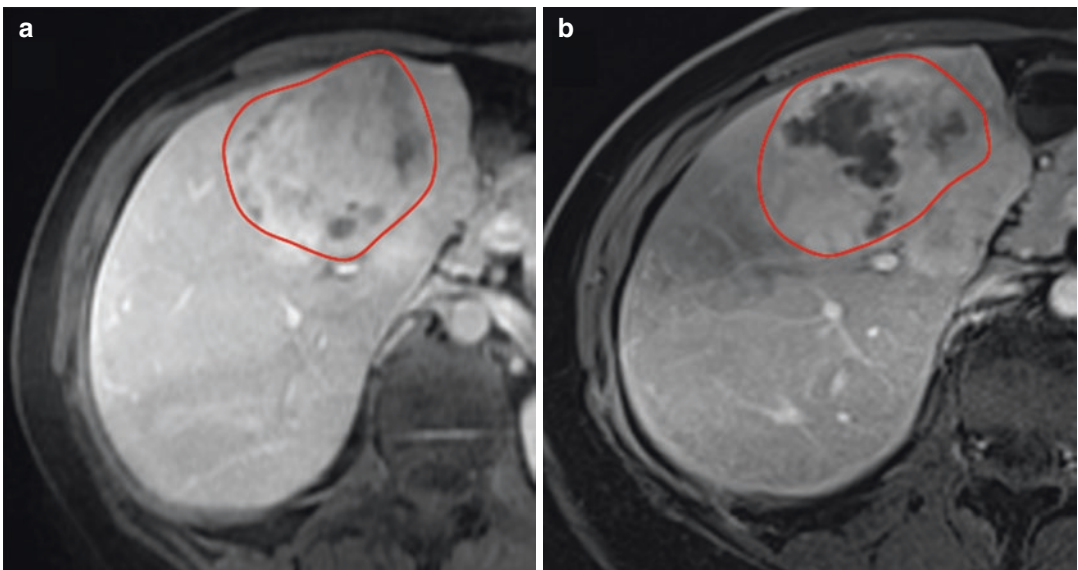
Cholangiocarcinoma at baseline (red circle) (a) and 1 month after TACE (b) on MRI shows minimal change in tumor size but considerable decrease in enhancement in response to TACE
